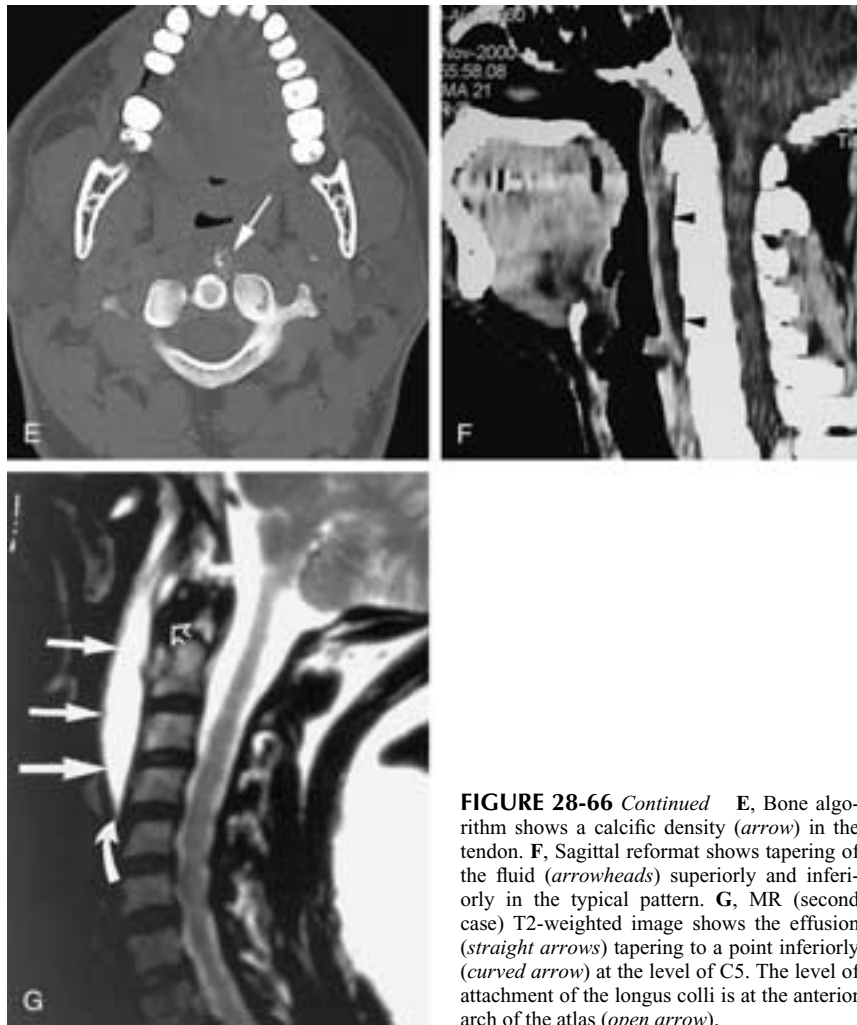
Continued* E, Bone algorithm shows a calcific density (*arrow*) in the tendon. F, Sagittal reformat shows tapering of the fluid (*arrowheads*) superiorly and inferiorly in the typical pattern. G, MR (second case) T2-weighted image shows the effusion (*straight arrows*) tapering to a point inferiorly (*curved arrow*) at the level of C5. The level of attachment of the longus colli is at the anterior arch of the atlas (*open arrow*).
